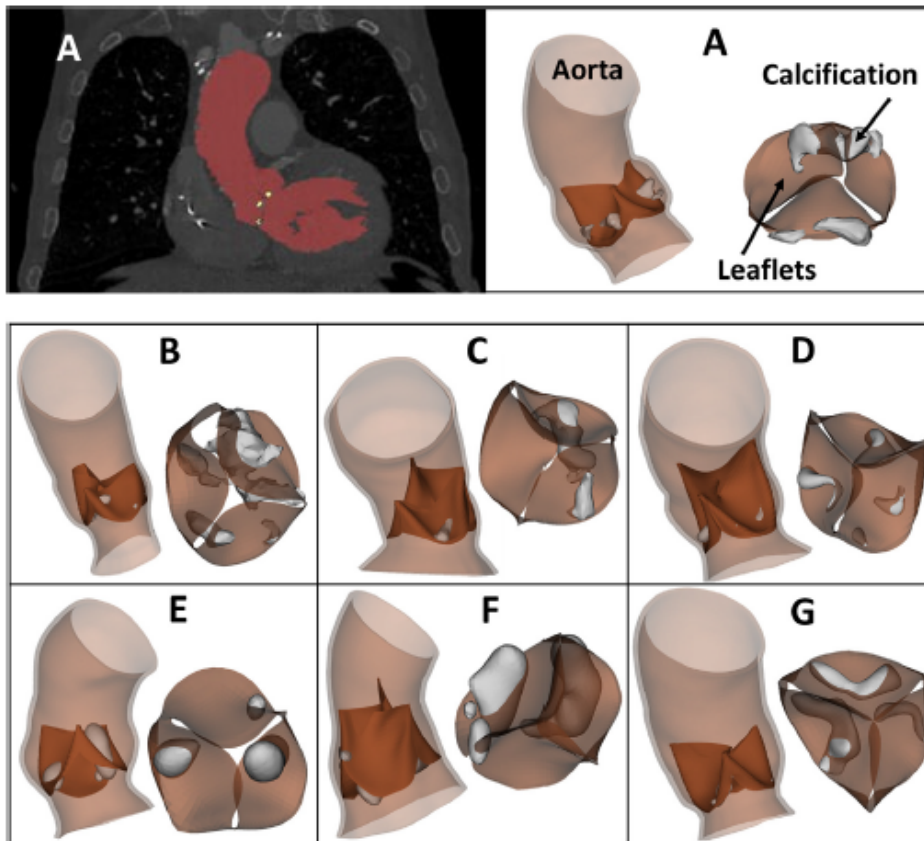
A) Example of segmented CT image and reconstructed geometries of aorta, native valve and calcification for the first patient. From B to G) geometries of all the other patients.^[6]
